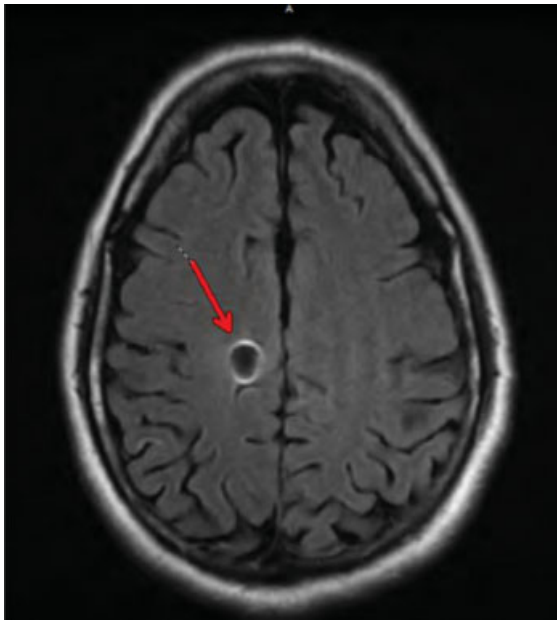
Magnetic resonance image (MRI) scan demonstrating the focal cerebral infarction at the site of the metallic embolization.
